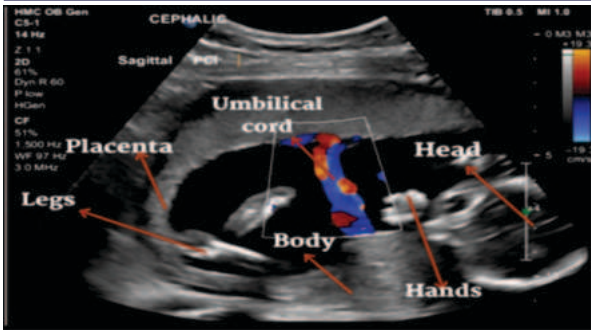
Utilizing Color Doppler Ultrasound for Fetal and Maternal Health Assessment in High-Risk Pregnancies
